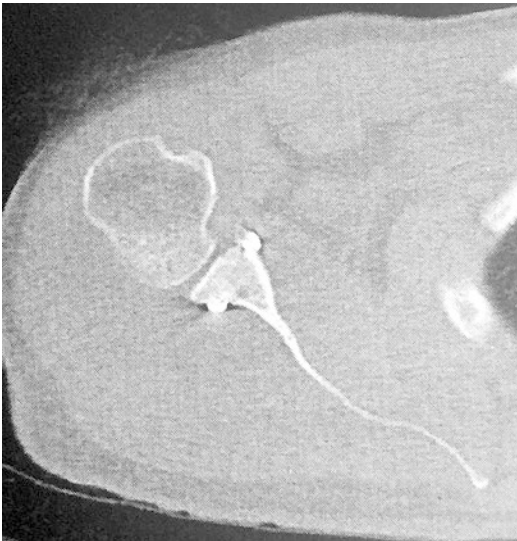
Postoperative CT scan at 1-year follow-up
